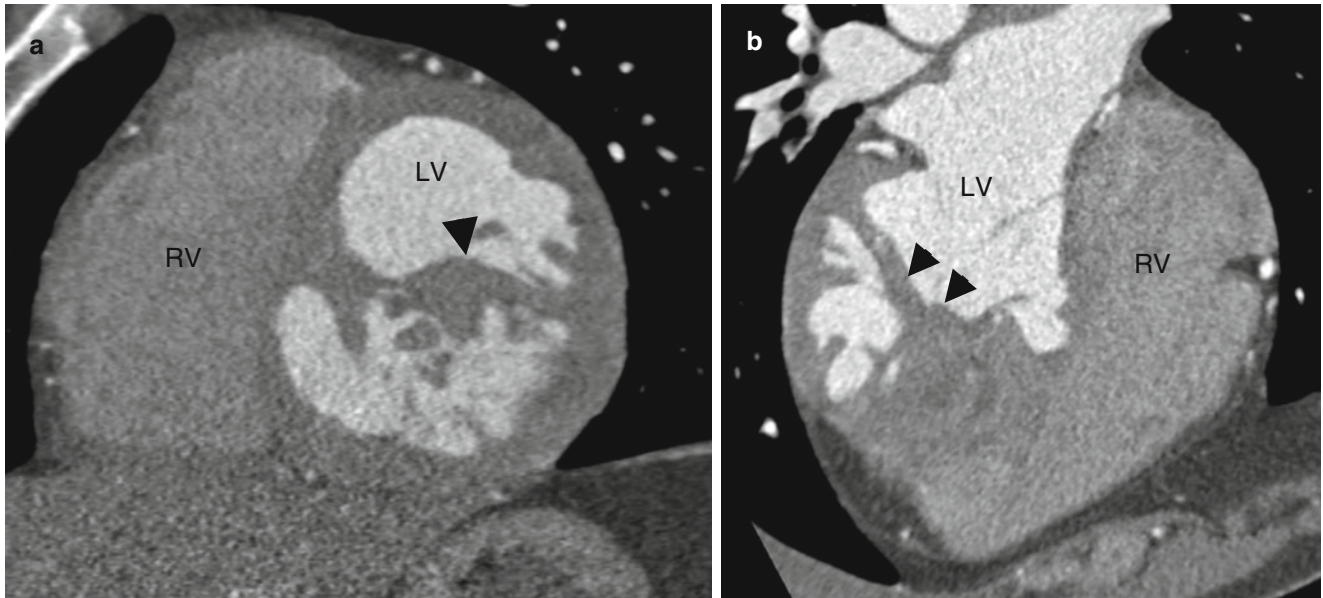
Parachute mitral valve. Panels (a, two-chamber computed tomogram) and (b, four-chamber view) show the chordae attached to a single thick papillary muscle or septation (black arrowheads) that
